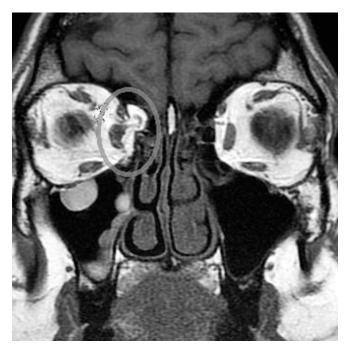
Coronal T1 MRI imaging demonstrating right medial rectus and periorbital fat contained in the ethmoid sinus.
